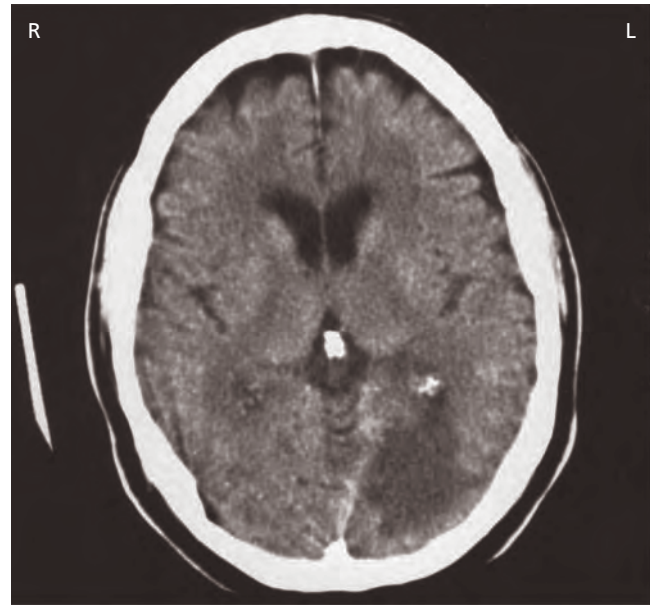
Infarction following posterior cerebral artery occlusion (unenhanced CT).
